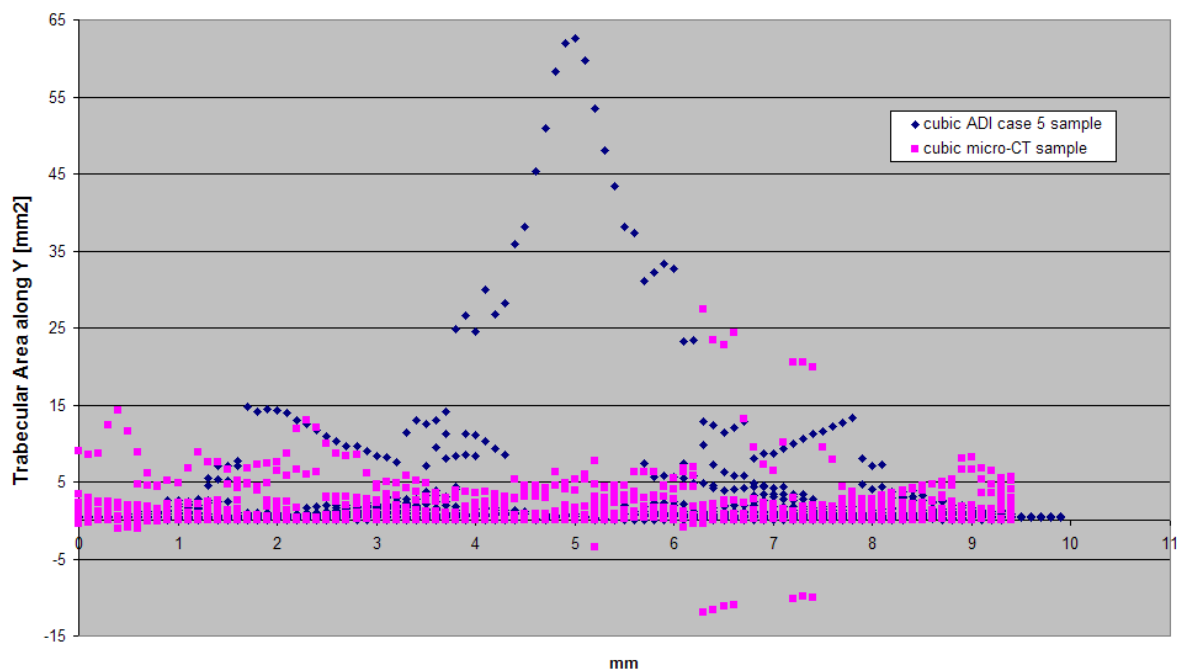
Comparison of sliced area along *Y* between the cubic ADI case 5 sample and cubic  $\mu$ CT sample
